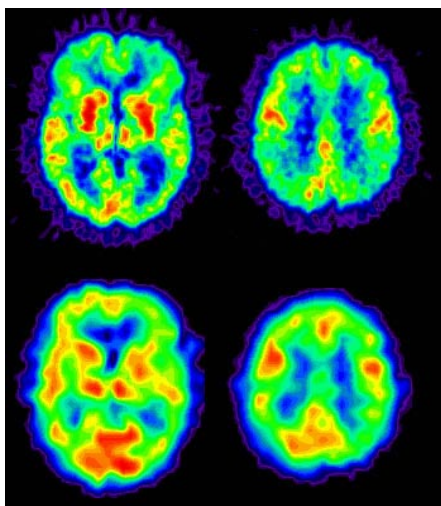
FDG-PET (*upper row*) and IMP-SPECT image (*lower row*) of a patient with DLB. This is a 68-year-old female who complained of fluctuating cognitive functions, recurrent visual hallucinations. MMSE score was 19. Both PET and SPECT images show diffuse metabolic or blood flow decrease in the whole brain excluding the primary sensorimotor area, basal ganglia and thalamus. This disease is characterized by decreased occipital metabolism on the PET image. However, the SPECT image does not clearly demonstrate a decrease in occipital blood flow.
